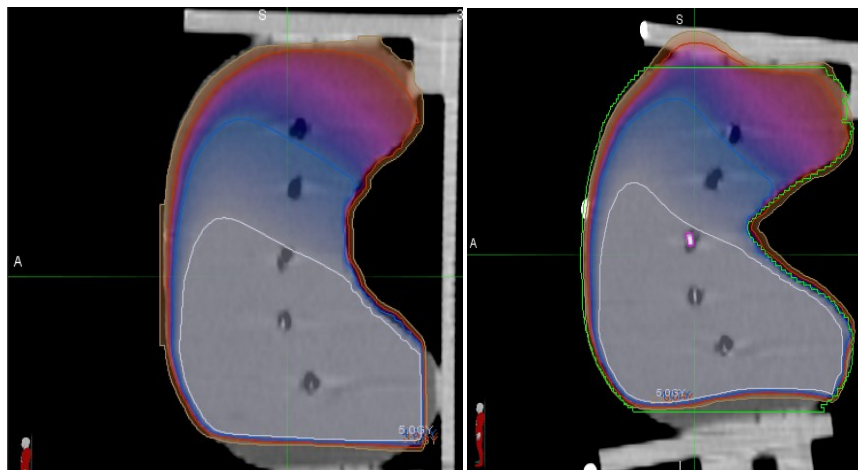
Sagittal view of 60 degree Enhanced Dynamic Wedge doses with original dose on original CT (left), and deformed old dose on deformed CT (right).
